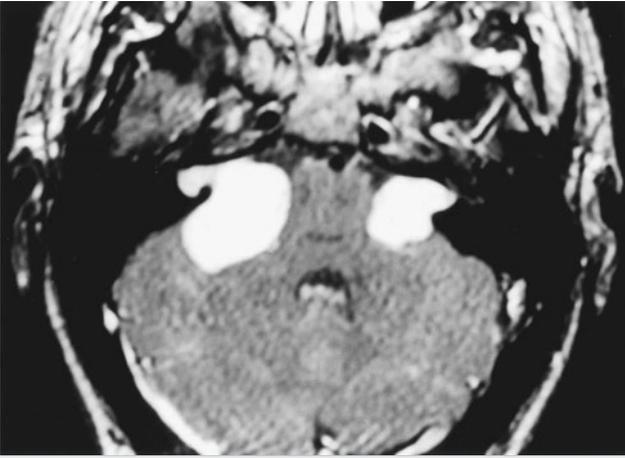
Magnetic resonance image of bilateral vestibular neurilemmomas in the 16-year-old son of a woman with known neurofibromatosis 2. On initial examination, he was noted to have unilateral blindness from a posterior cataract and right-sided deafness that reportedly had developed insidiously. The larger, right-sided vestibular lesion was resected uneventfully, and the left-sided lesion was observed while the patient learned sign language and lip reading.
